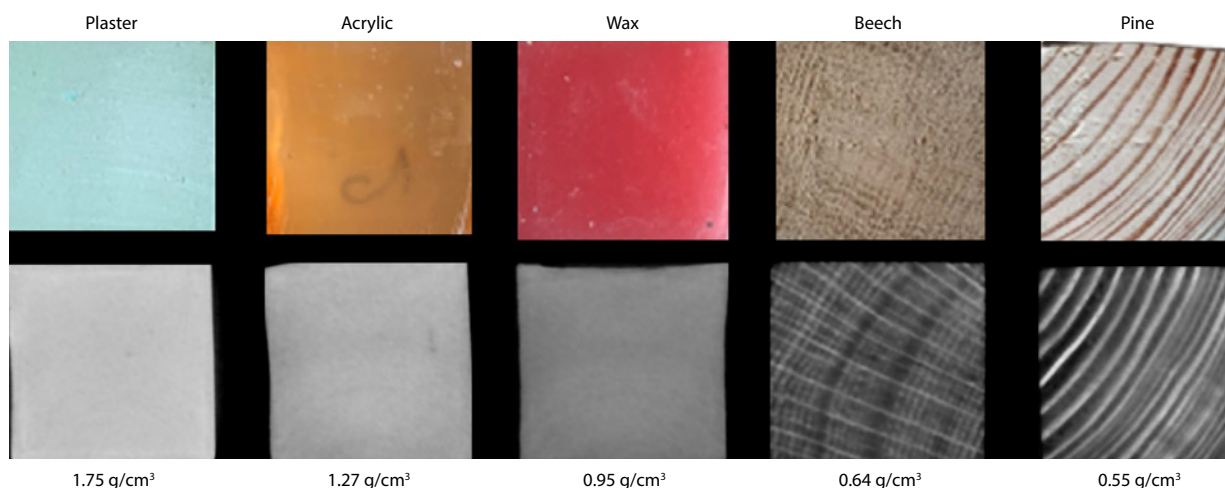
Physical images, cone-beam computed tomography (CBCT) scans, and physical densities of the evaluated materials, including plaster, acrylic, wax, pine, and beech
